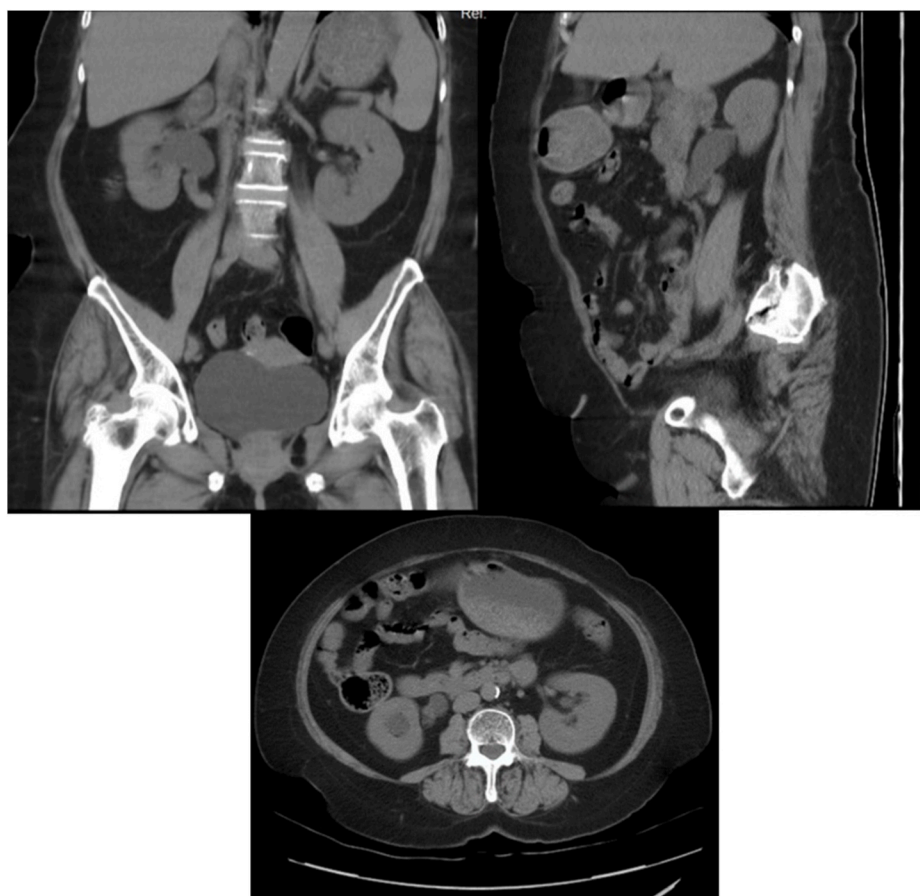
Non contrast Abdominal CT. Right hydronephrosis and hydroureter with solid homogenous mass in right proximal ureter with size 20x10x10 mm.
